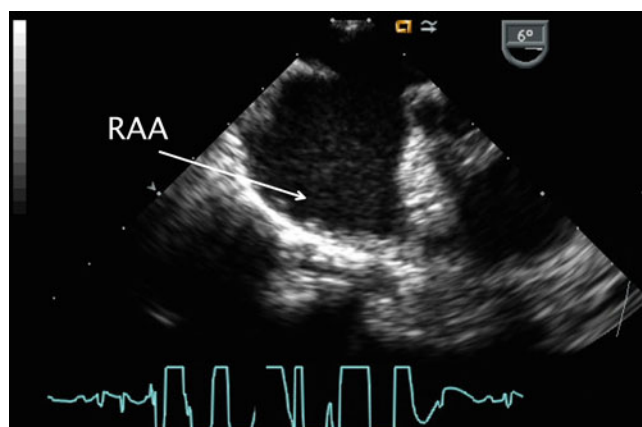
Transesophageal image displaying the broad-based right atrial appendage (RAA). There is also a moderate to large secundum atrial septal defect present
